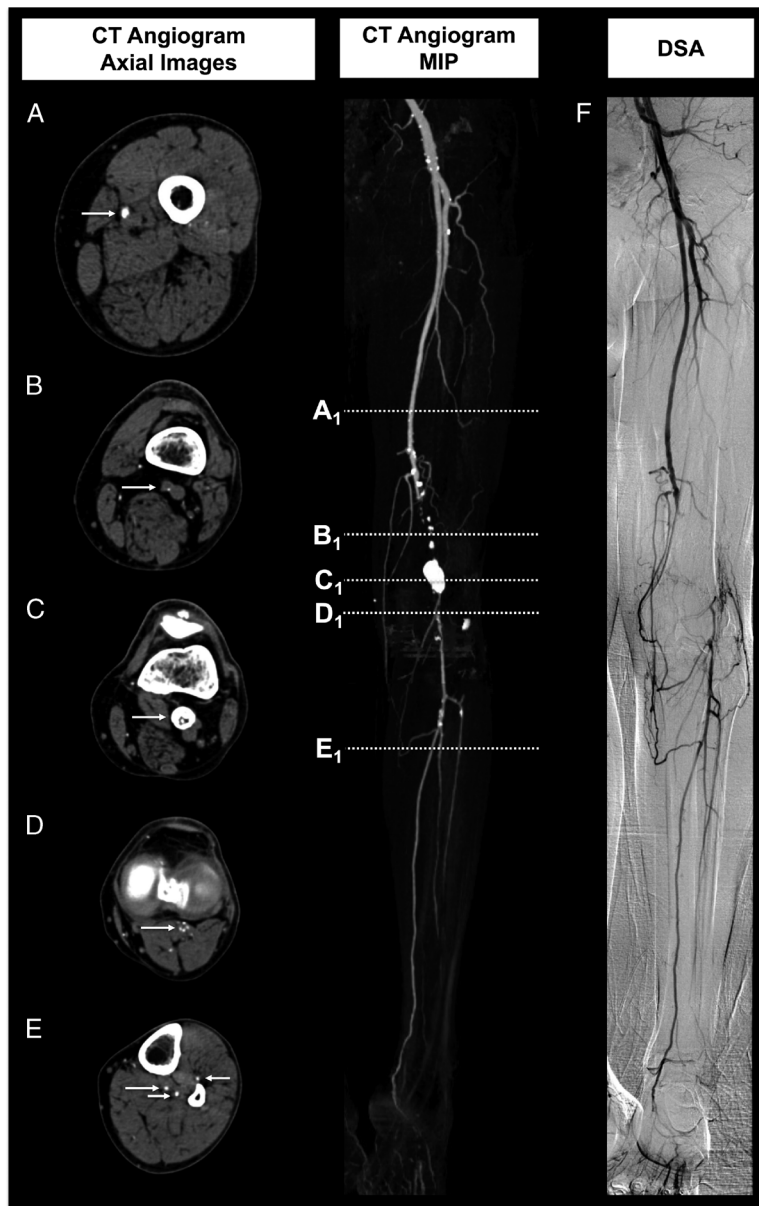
CT and digital subtraction angiography (DSA) in a 65-year-old man with peripheral arterial disease (PAD), calf claudication, and an occluded popliteal aneurysm. Four years ago, the patient developed moderate claudication, which resulted in evaluation by CT angiography (A–E) that revealed occlusion of the popliteal artery proximal to the knee (B) and at the site of an extensively calcified aneurysm at the level of the knee (C). CT angiography also demonstrated that the popliteal artery was reopacified distally by collateral vessels (D). The trifurcation distal to the popliteal remained unremarkable with 3-vessel runoff (E). One month after CT angiography, there was worsening of claudication symptoms that led to an abdominal aortogram with runoff using DSA (F). DSA demonstrated popliteal artery occlusion above and at the level of the knee, with reconstitution slightly below the knee and 3-vessel runoff. No intervention was performed, and medical management with aspirin and acetaminophen as well as recommendations for smoking cessation and walking therapy were pursued. Cilostazol was prescribed, which resulted in marked improvement of symptoms, thereby enabling conservative management over subsequent years.
